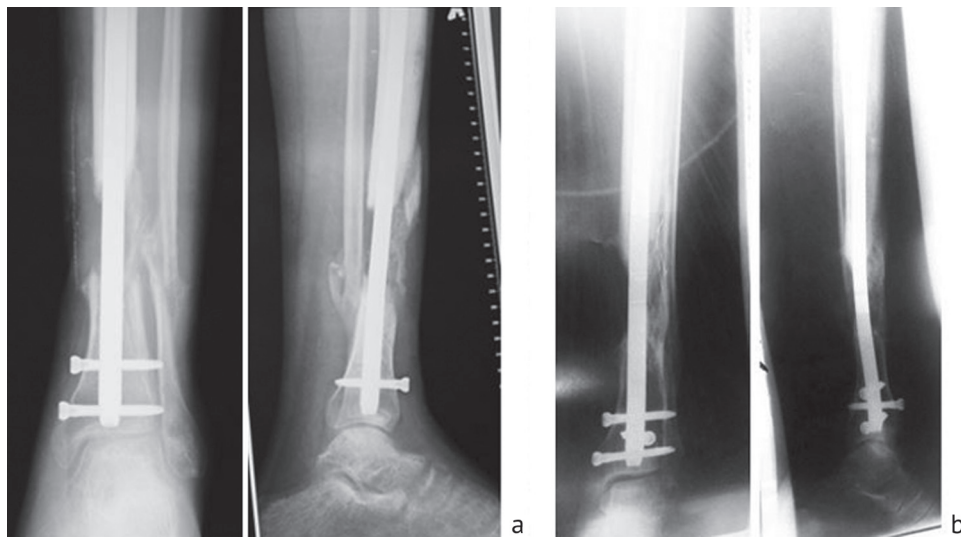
Radiographs of the lower leg of patient K., 20 years old, 6 months (a) and 1.5 years (b) after the injury (images sent by the patient via the Internet)
